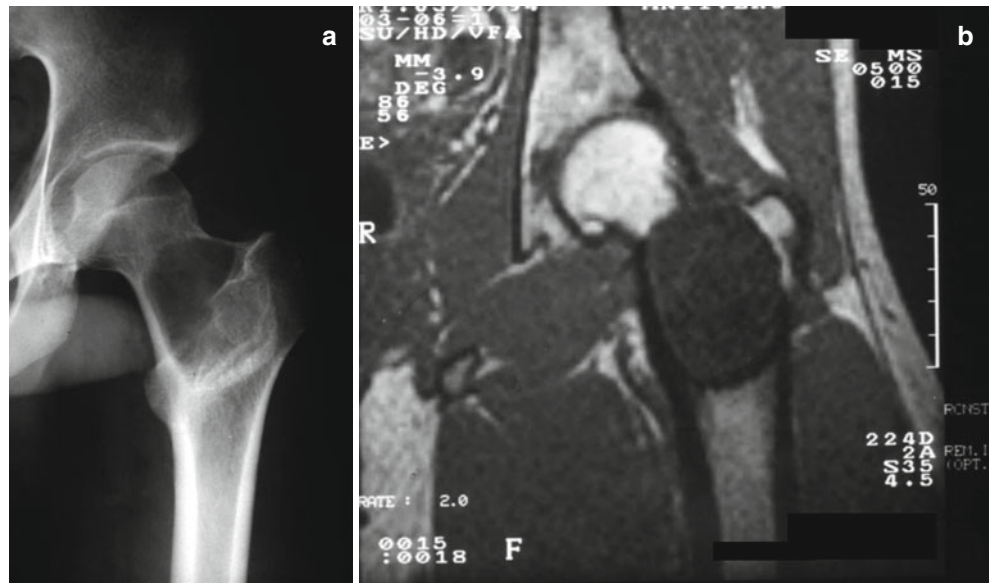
FD. Radiographic features. Anteroposterior view of the right hip shows isolated lesion in metaphyseal-diaphyseal region with a typical “ground-glass” feature
